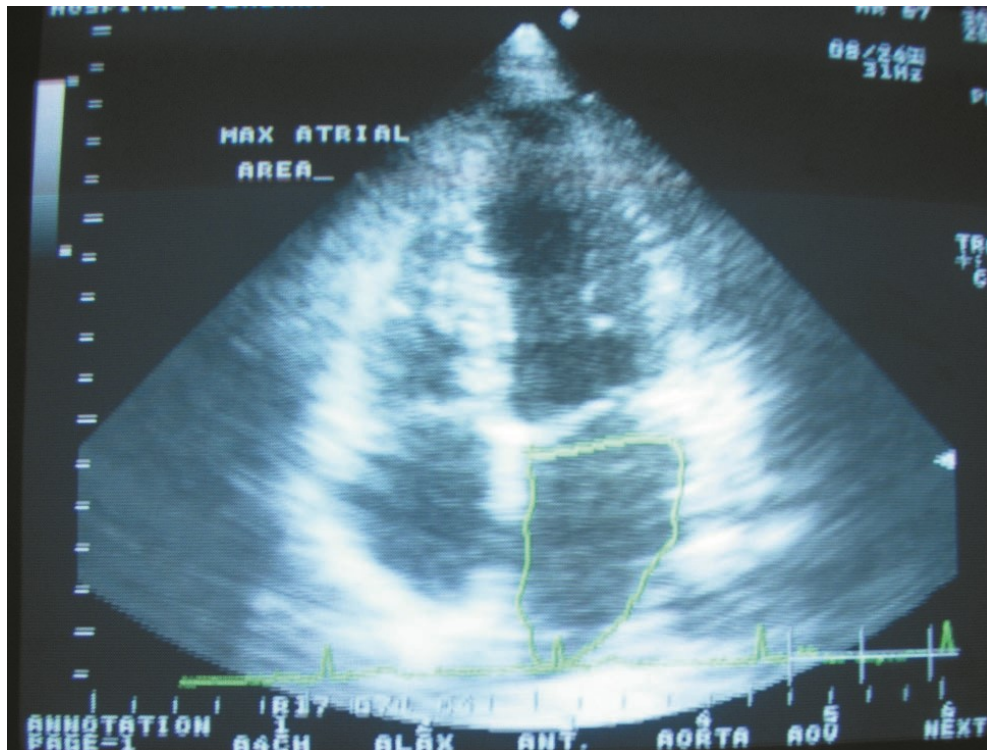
Echocardiogram Showing Measurement of maximal left atrial area.
